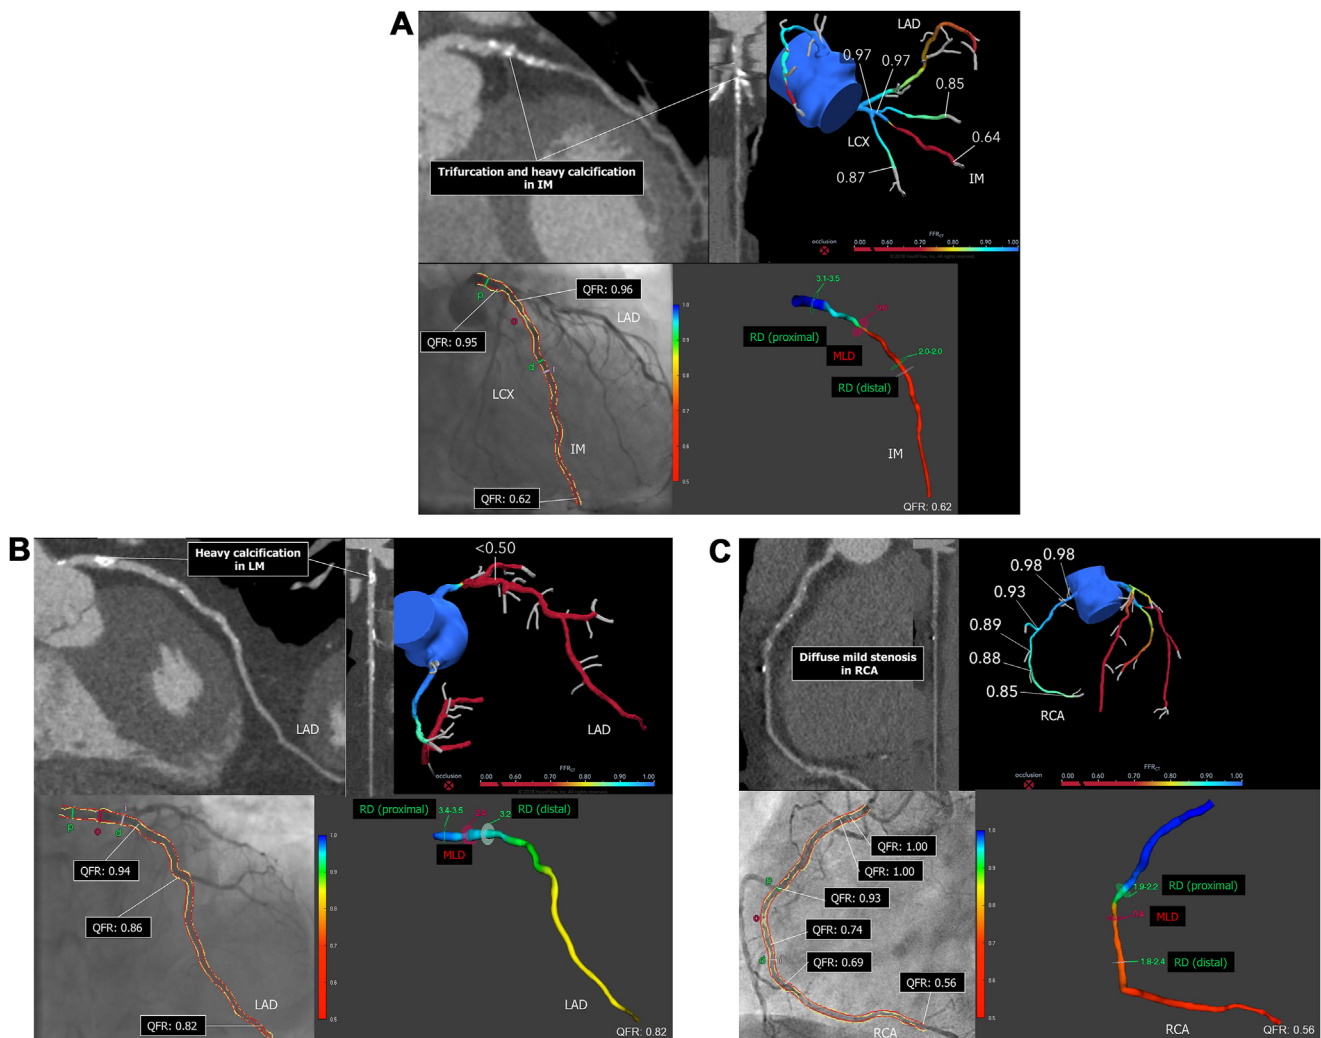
Diagnostic concordance and discordance between FFR_{CT} and QFR. (A) Diagnostic concordance between FFR_{CT} and QFR. Top left panel: Curved MPR and straight MPR images in IM. Top right panel: FFR_{CT} analysis in IM. Bottom panel: QFR analysis (LM to IM). (B) Diagnostic discordance between FFR_{CT} and QFR (Positive FFR_{CT} and negative QFR). Top left panel: Curved MPR and straight MPR images in LAD. Top right panel: FFR_{CT} analysis in LAD. Bottom panel: QFR analysis (LM to LAD). (C) Diagnostic discordance between QFR and FFR_{CT} (Negative FFR_{CT} and positive QFR). Top left panel: Curved MPR and straight MPR images in RCA. Top right panel: FFR_{CT} analysis in RCA. Bottom panel: QFR analysis (RCA). FFR_{CT}: fractional flow reserve derived from computed tomography; QFR: Quantitative flow ratio; MPR: multiplanar reconstruction; IM: intermediate artery; RCA: right coronary artery; LM: left main trunk; LAD: left descending artery; LCX: left circumflex; RD: reference diameter; MLD: minimum lumen diameter.
